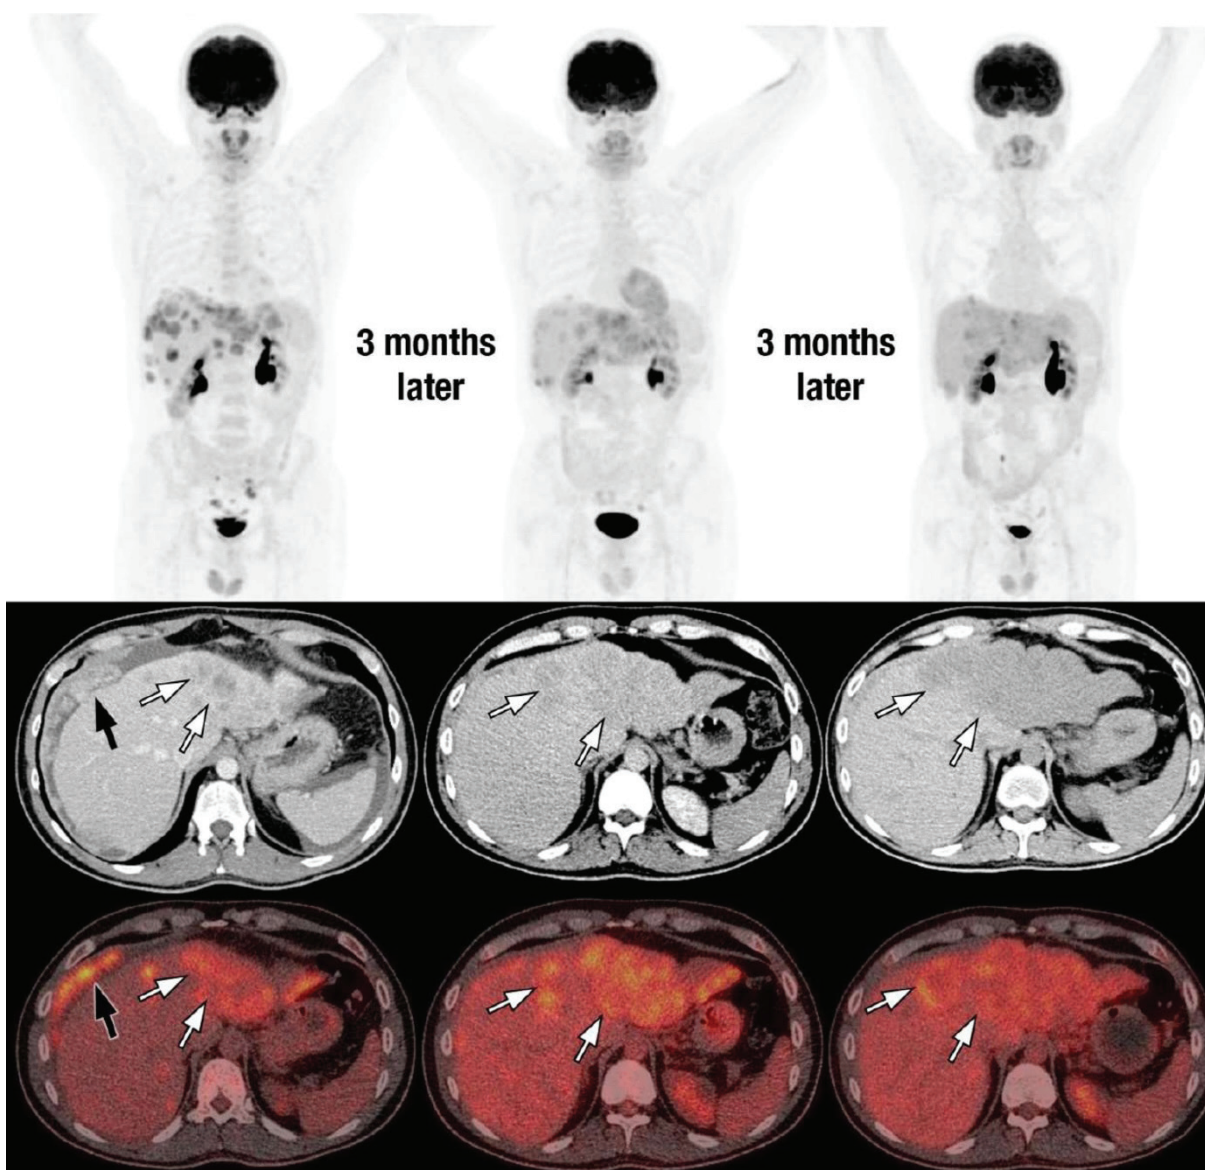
In the sequential imaging (PET-CT) of the same patient taken at three-month intervals, the initial examination reveals perihepatic intraperitoneal malignant lesions denoted by black arrows, which are notably absent in the subsequent images. Conversely, liver lesions, indicated by white arrows, display a progressive increase in size over the observed period.
